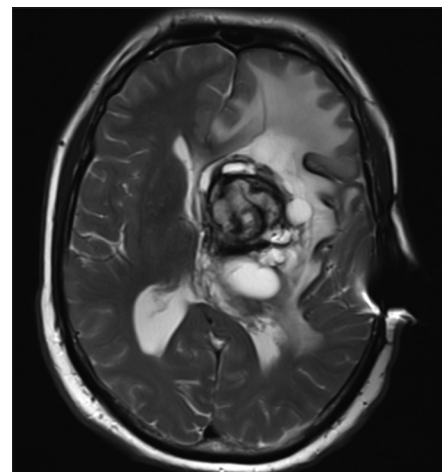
T2-weighted axial image demonstrates multilocular cyst with surrounding vasogenic edema. Measured midline Shift of 9 mm.
